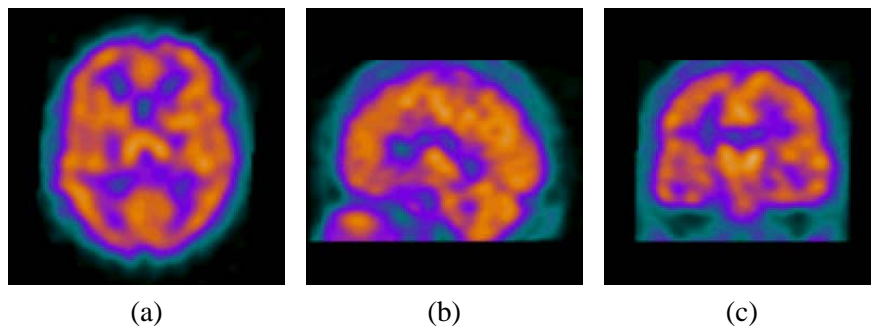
An activation from a SPECT image of the brain, showing transaxial, sagittal, and coronal slices. See page 65 for a colour version of the figure.
